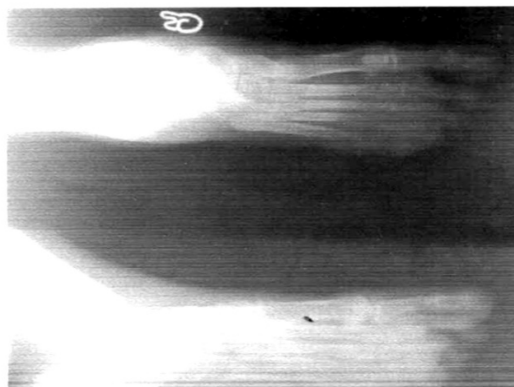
Radiographic evidence of advanced osteolysis involving the distal and middle phalanges of the fifth toe of the left foot, associated with lysis of the base of the fourth metatarsal. Additional incomplete osteolysis of the middle phalanx of the fourth toe is observed, complicated by interphalangeal dislocation. The osteolytic pattern appears elongated and tapered, corresponding to a so-called “sugar-cane” appearance, with focal eraser-like osteolytic defects.
